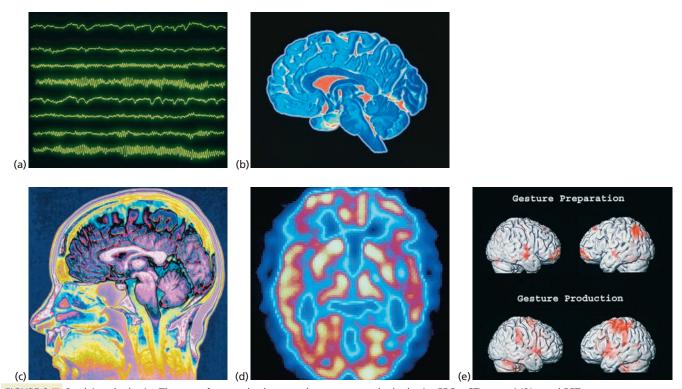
Studying the brain. These are four methods researchers use to study the brain: EEGs, CT scans, MRIs, and PET scans.
